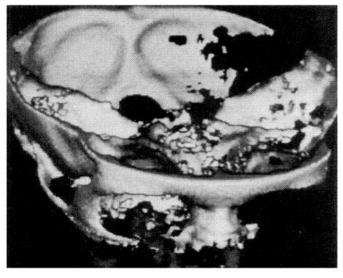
Three-dimensional computer reconstruction of CT scans (mirror image) of the lower half of the GSD patient's skull before treatment. The calvaria is not shown in this representation. The mandible and right maxilla are totally resorbed, and the zygoma, right parietal bone, and cranium have progressively resorbed.
